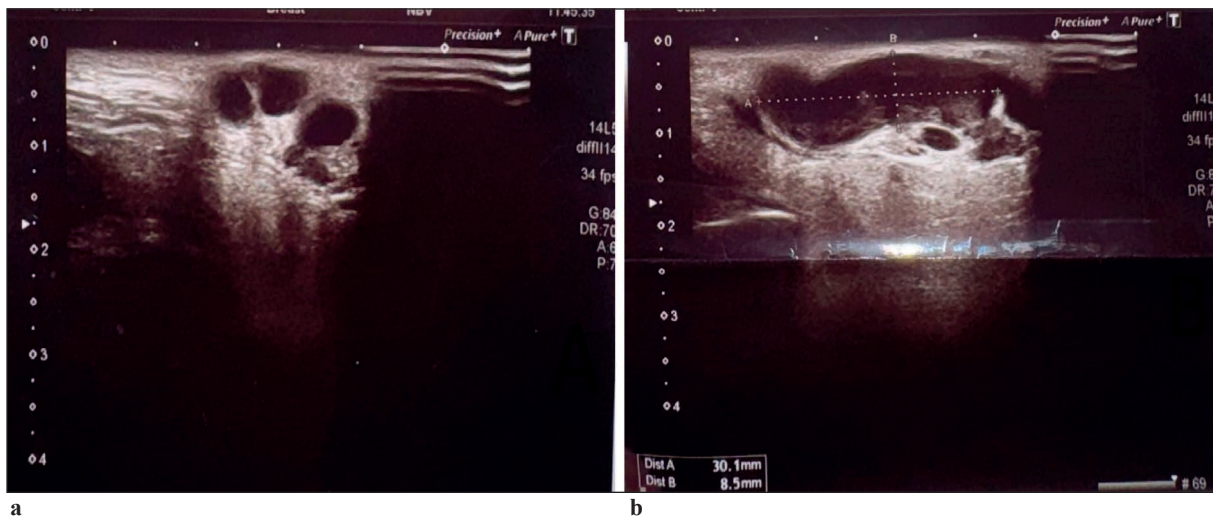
a and b. Ultrasound of the right parotid salivary gland.
